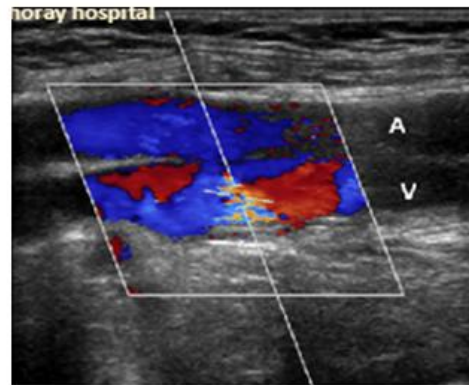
Ultrasound findings showed a fistula between the common femoral artery and the femoral vein
